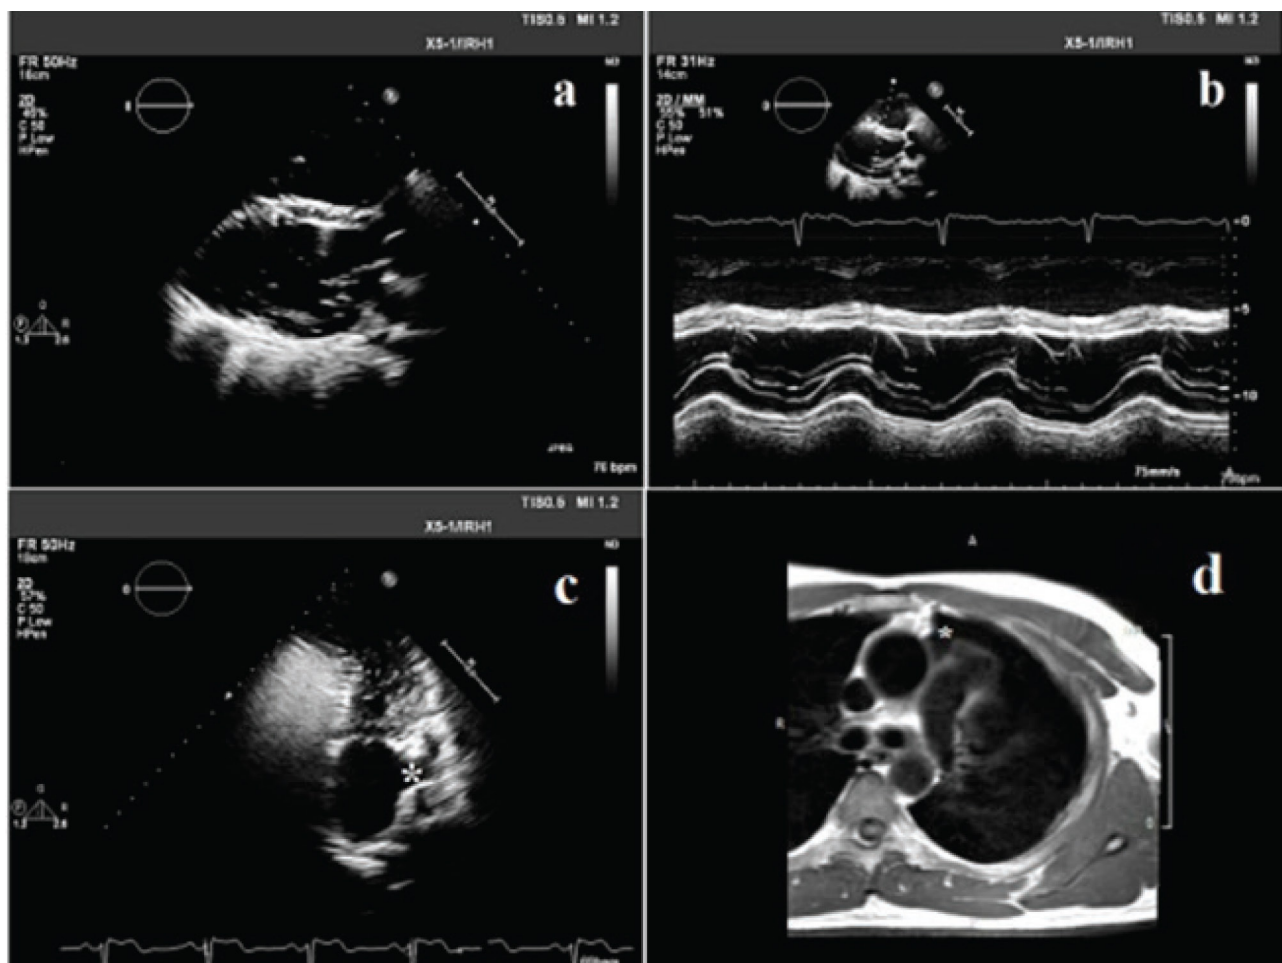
a. Posterior Deviation of the Heart in Parasternal Long Axis View; b. Abnormal Septal Motion in M-mode Echocardiography: Flattening of the Inter-Ventricular Septum in Systole and Paradoxical Motion in Diastole; c. Apical Two Chamber View of the Left Heart, Asterisk Denoting to the Elongated Left Atrium Auricle (the Star); d. Cardiac Magnetic Resonance Imaging Images Revealed Interposition of the Lung between the Aorta and Pulmonary Artery (the Star).
